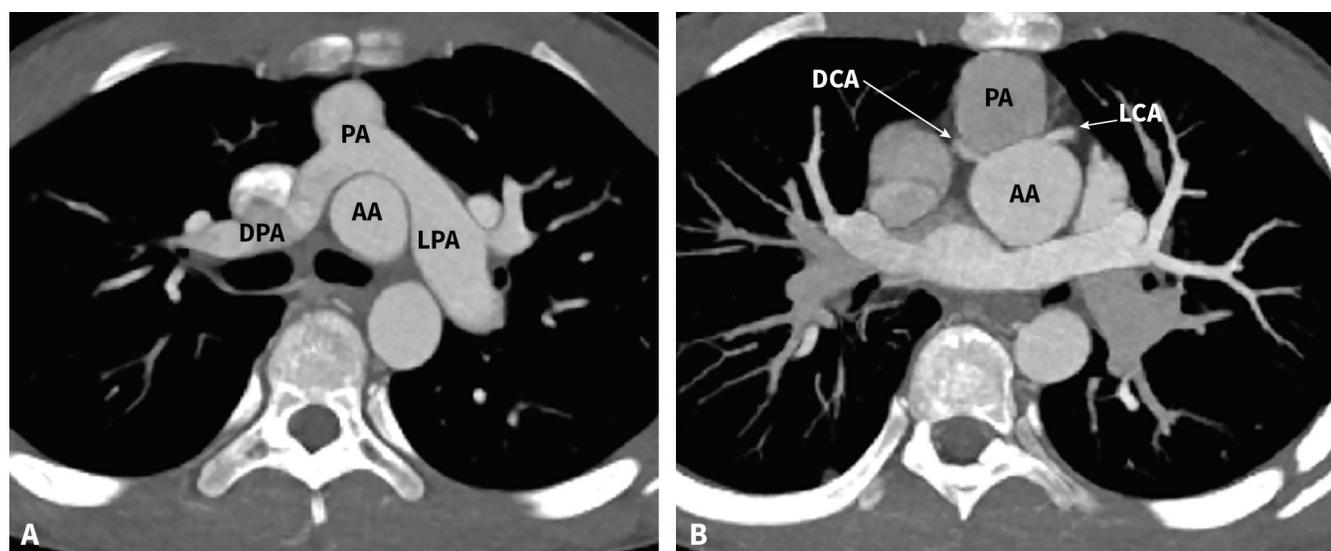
Computed tomographic angiogram (CTA) after the arterial switch operation (ASO) in a patient with D-transposition of the great arteries (D-TGA) - normal.
